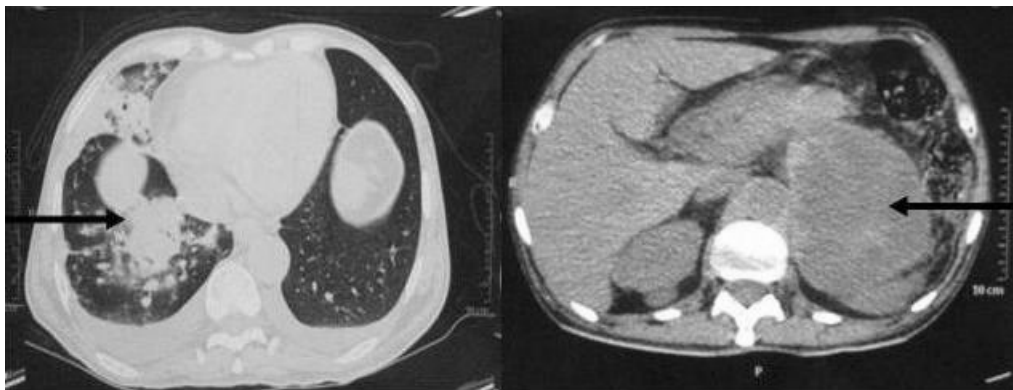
CT Thorax with Abdomen showing large adrenal mass with infiltrations in right lung.
